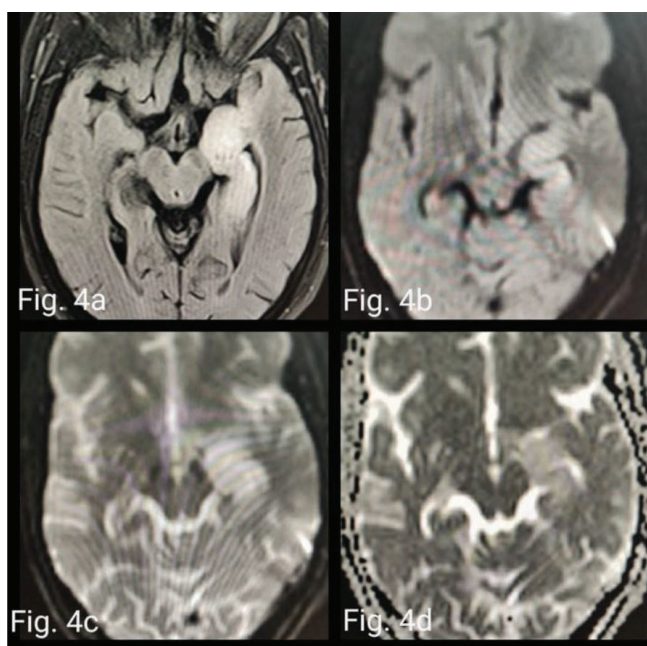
Axial FLAIR (a) image shows high signal intensity in the left medial temporal lobe. DWI-b500 (b), b1000 (c) and corresponding ADC (d) map shows free diffusion in the left medial temporal lobe.
